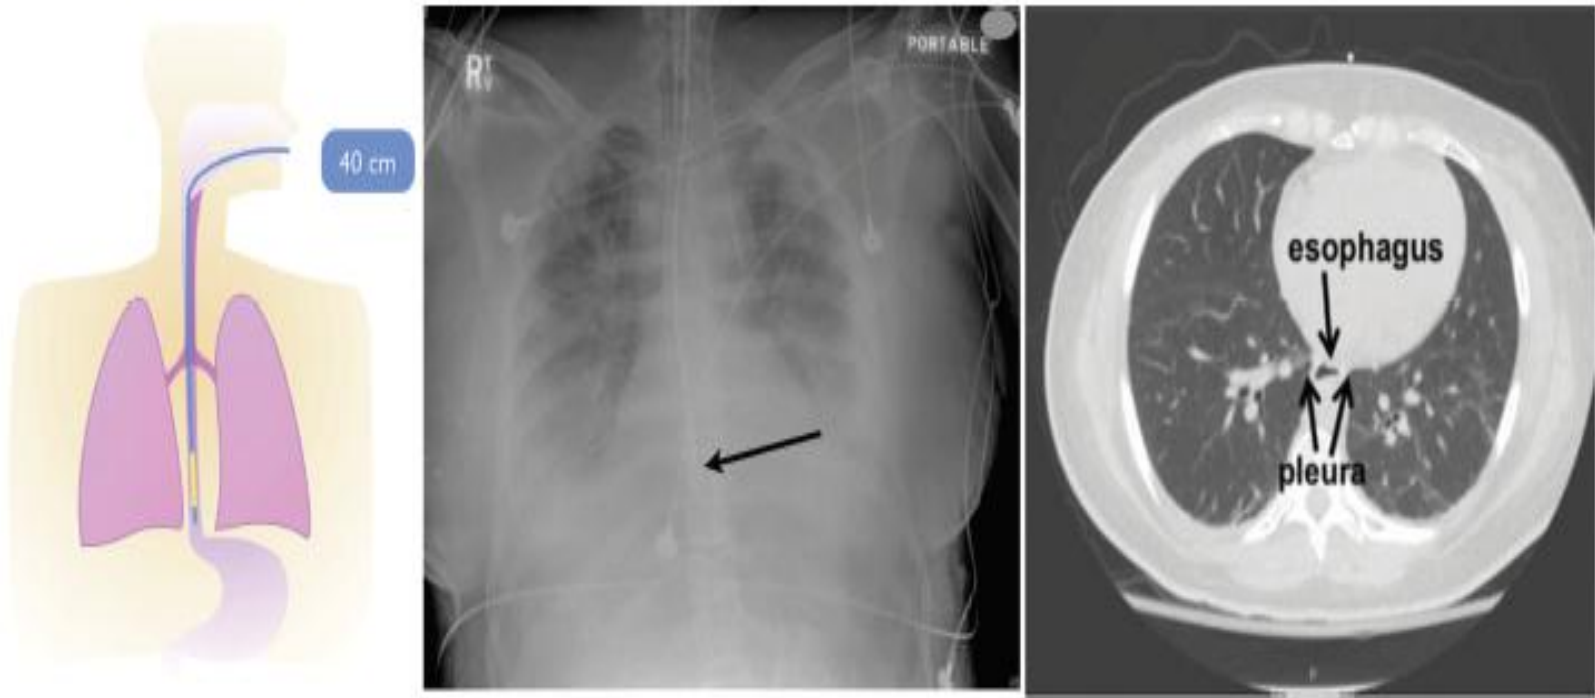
Left: Correct positioning of the esophageal balloon, ~40 cm from the lips. Center: Chest radiograph showing correct balloon placement (arrow). Right: Note that the esophagus borders the pleural space in the mid-thorax (arrows). Left and center images from Reference 19.
